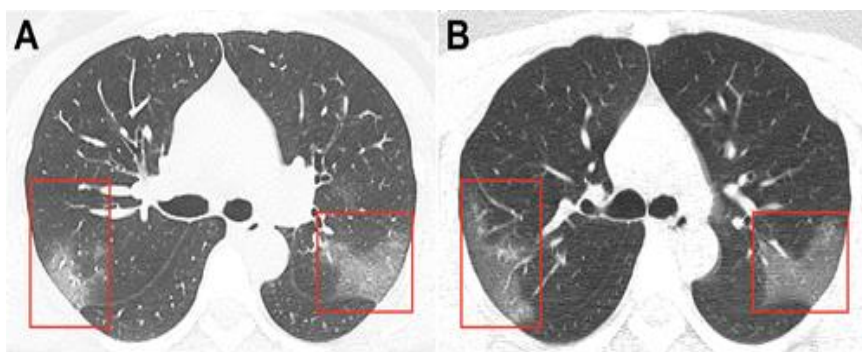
Bilateral peripheral pulmonary opacities, without subpleural sparing, are common CT findings of new coronavirus pneumonia in 2019
